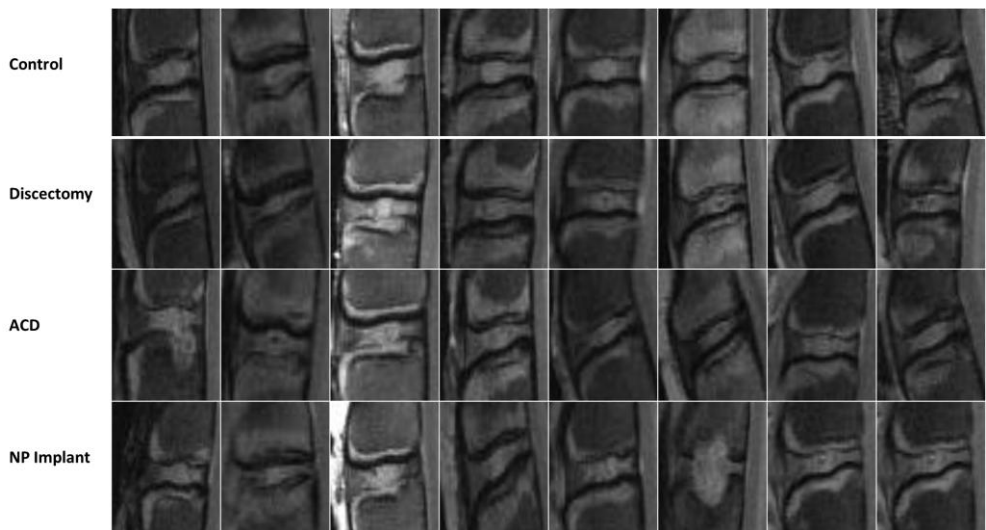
Sagittal MR images of all levels after 6 weeks follow-up. The first image of the ACD series and the sixth image of the NP implant series reveal a tissue reaction. The first case only one endplate is destructed, whereas both endplate are involved the latter.*
